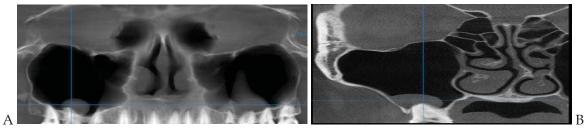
A) OPG image from CBCT; B) CBCT image, coronary section
